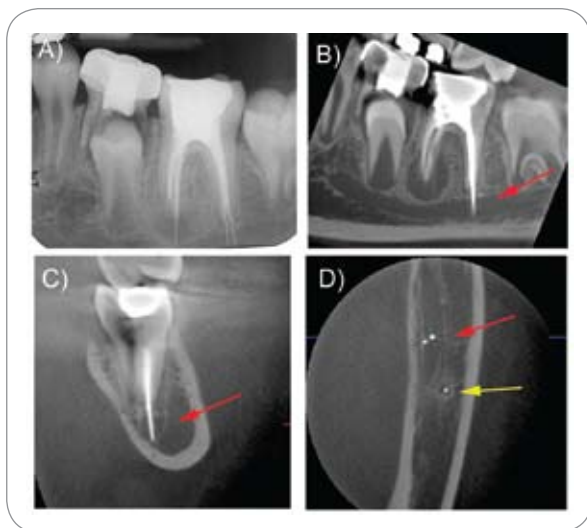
Periapical radiograph (A), sagittal (B), cross-sectional (C), and axial (D) CBCT sections of tooth No. 18. Red arrow points to the endodontic cone in the distal, while yellow arrow points to the endodontic cone in the mesial root of No. 18.
